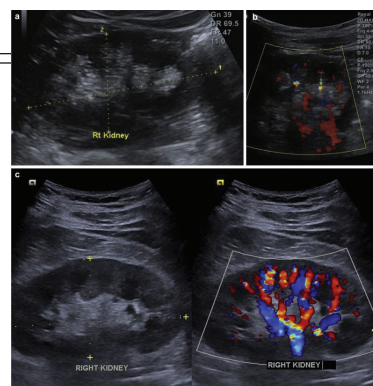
Diffuse hyperechogenicity of renal medulla on B-mode ultrasonography. (b) Color Doppler ultrasonography showing numerous twinkling artifacts (green arrow). (c) Ultrasonographic image of a normal patient. Note that the renal medulla is hypoechoic as compared to the cortex on B-mode scanning, and there is no twinkling artifact on color Doppler (right).
